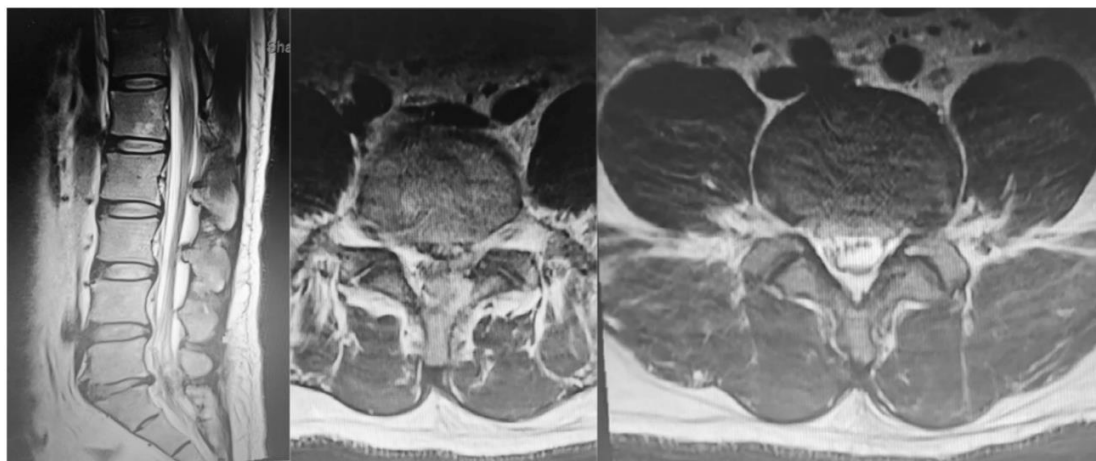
Postoperative MRI view. L5 / S1 spinal canal decompression is sufficient, and there is no obvious hematoma compression.
